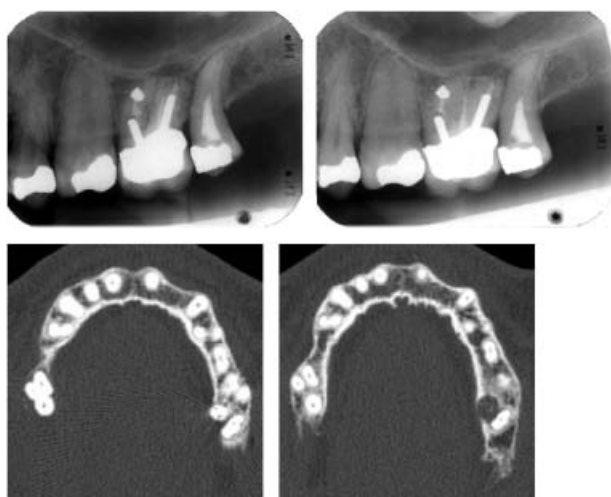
Intraoral radiographs of the upper left first molar and two cropped computed-tomography images showing more detailed information about the condition of the tooth, e.g. the large lesion at the palatal root.
